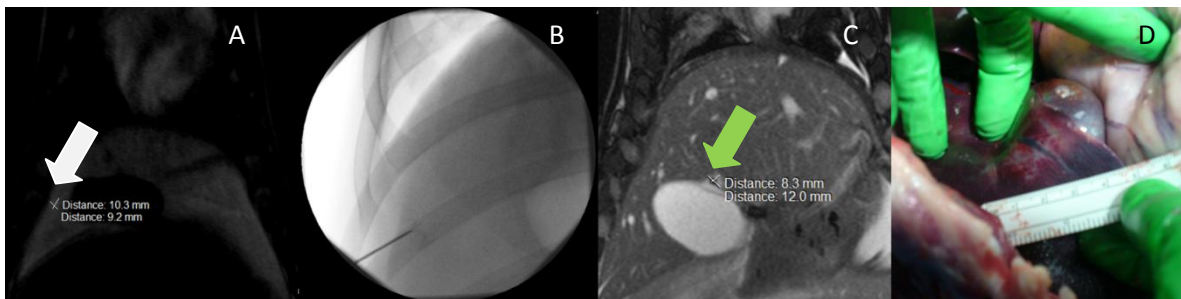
A: MR image (TWIST 4D) used for treatment planning in the liver (white arrow) B: Needle placement in the liver (Fluoroscopy image); C: Post-ablation MRI (True FISP), showing a very small ablated area near the gallbladder in (green arrow); D: Necropsy image showing the ablated area in the liver (purple arrow). Probably, during the treatment probe was moved into the gallbladder.
